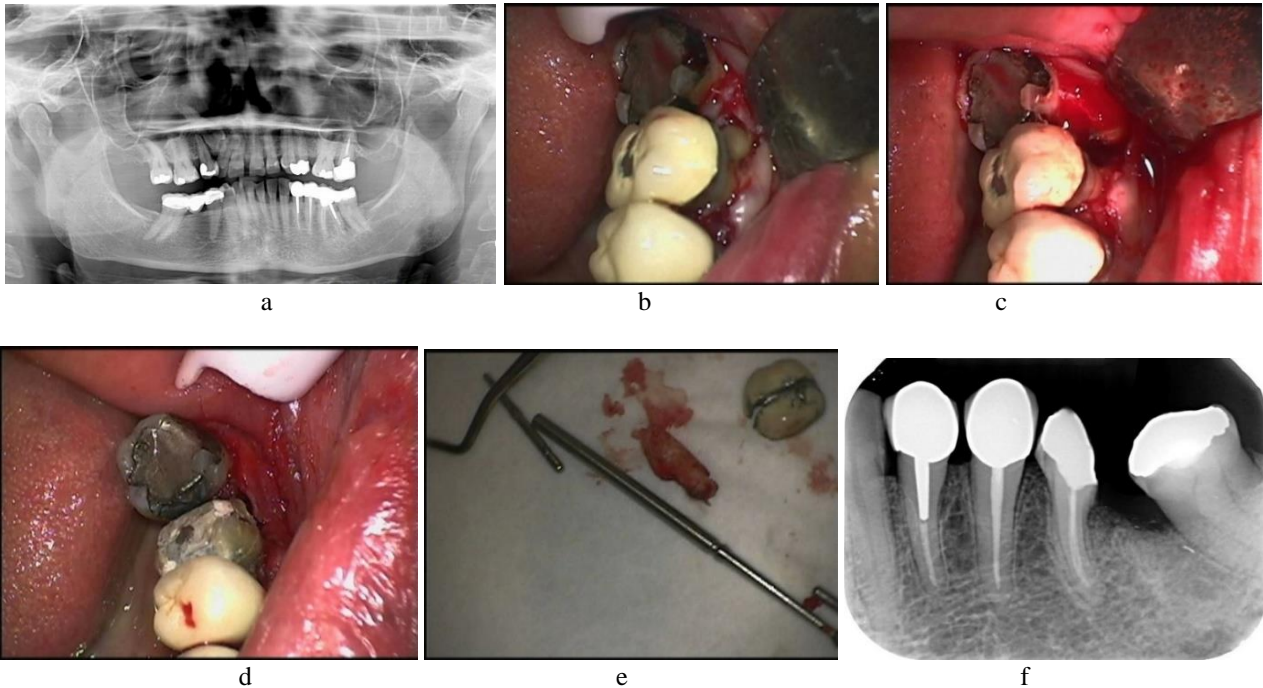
A case of distal root resection of crowned and root filled tooth 36 referred to the prosthodontist. a. preoperative radiograph b. flap raised exposing the two roots of 36. c. resection of the distal root. d. removal of the crown and the distal segment of 36. e. The resected root. f. postoperative radiograph
